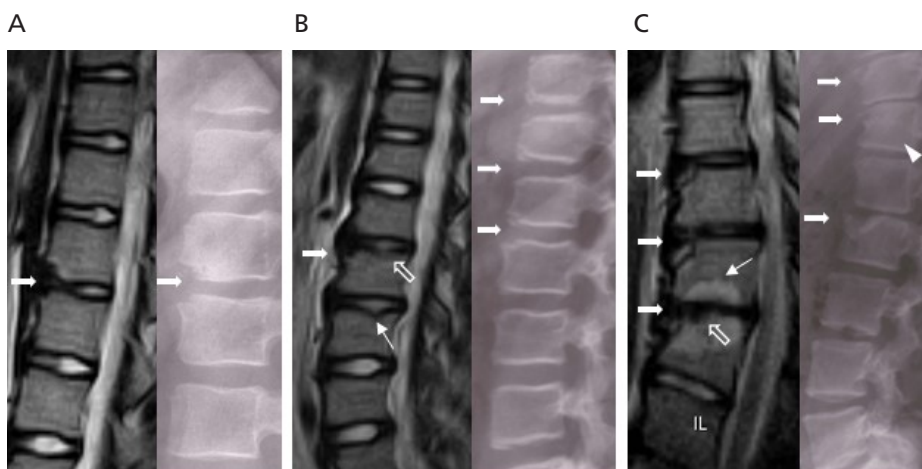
Findings on spinal MRI in patients with severe JIA.
